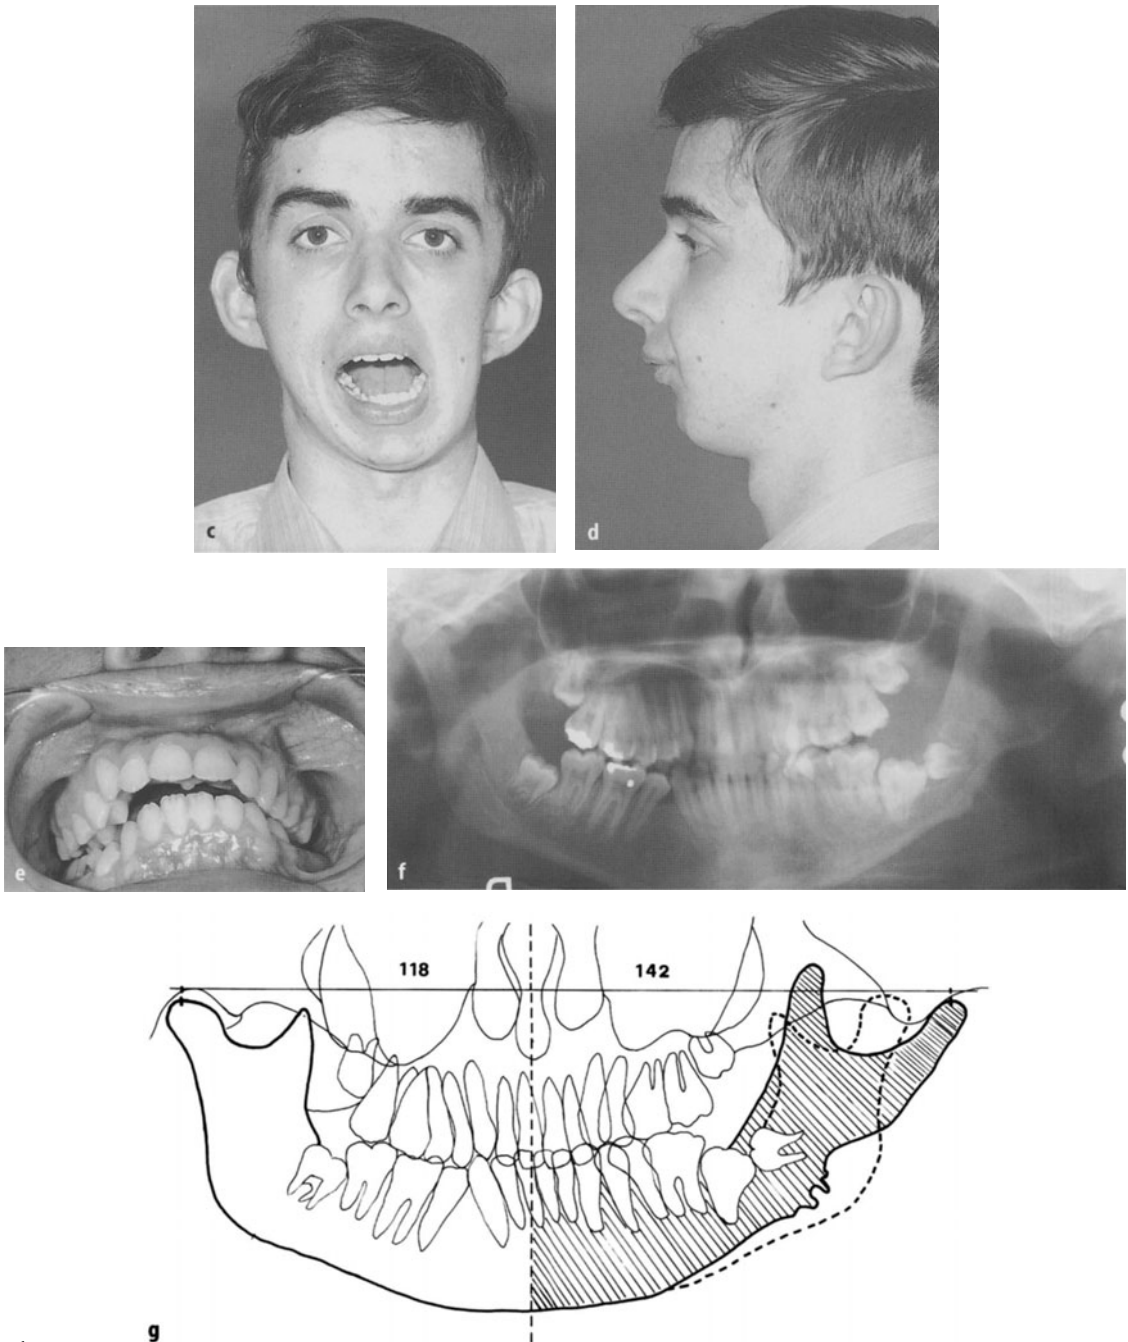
Hemimandibular and hemimaxillary hypoplasia due to a perimandibular and perimaxillary cavernous haemangioma. a–e Patient's appearance and occlusion is very similar to a hemifacial microsomia anomaly. f The panoramic view discloses an atypical deformity of the left half of the mandible with a short ascending ramus without any gonial angle, but with a very long coronoid and a long and deformed condylar process. The latter reaches further laterally than the one on the normal side. g On a tracing of the panoramic radiograph (with the courtesy of H. Sailer), the difference between the left and right halves of the mandible becomes very obvious when the normal hemimandible is projected over the abnormal one
